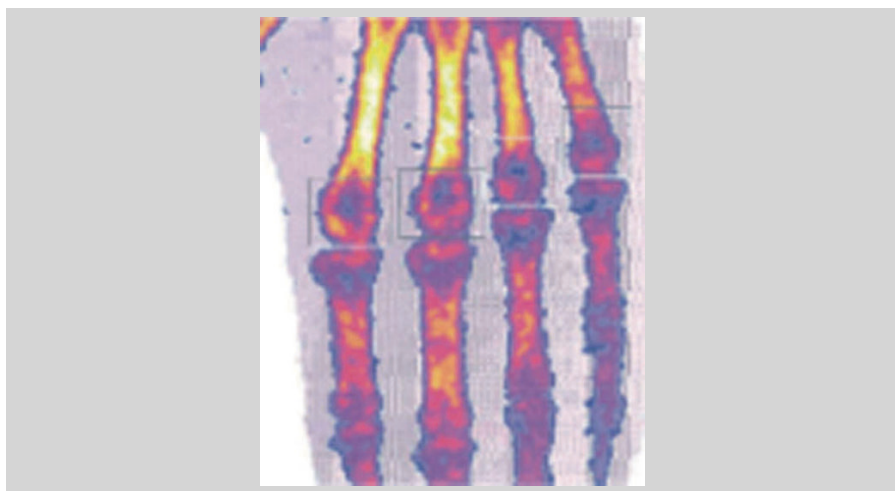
Hand bone densitometry by dual energy X-ray absorptiometry: measurement of metacarpal heads. The image shows measurement of hand bone mineral density using a limited area selected for analysis. Rather than choosing the entire hand, the juxta-articular distal (1.5 cm) of the metacarpal bones are included in this analysis. This method had 1.6% coefficient of variation for duplicate measurements. Reproduced with permission from Jensen et al [14] ©BMJ.
